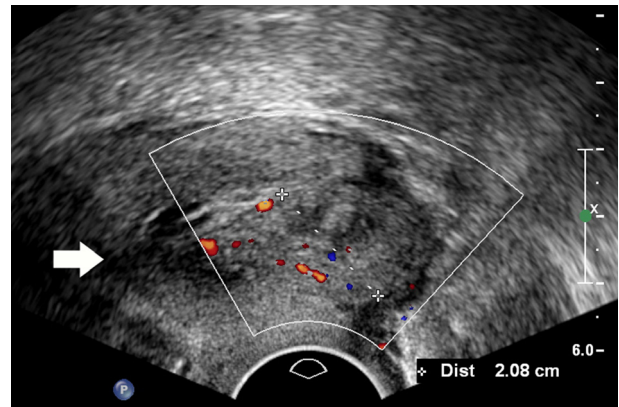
Transvaginal ultrasound, sagittal view of the cervix: 21 mm myoma in the external orifice of the cervix. The vascular end-foot ascends to the cervical canal. The arrow shows the internal opening of the cervix.
